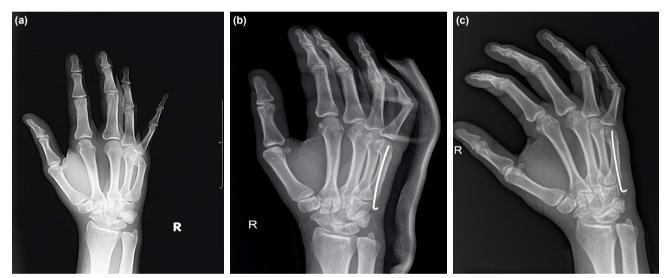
(a) X-ray of the case sample with fifth metacarpal neck fracture. (b) X-ray of the case sample showing that anatomical reduction and fixation can be achieved. (c) Final follow-up control X-ray of the patient sample in whom anatomical reduction could not be achieved.
